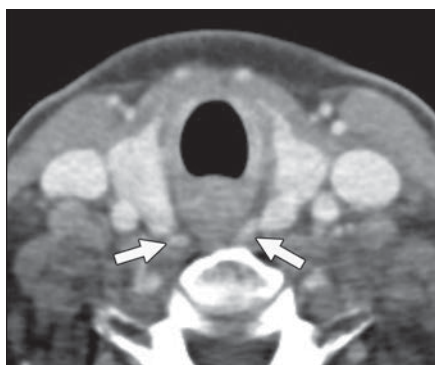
52-year-old woman with history of breast cancer who underwent contrast-enhanced neck CT owing to palpable left supraclavicular abnormality. Axial image shows small bilateral central compartment nodules (arrows) appearing separate from adjacent thyroid gland and exhibiting enhancement different from that of lymph nodes elsewhere in neck. Interpreting neuroradiologist suspected this finding to represent opportunistically identified enlarged bilateral superior parathyroid glands and included in clinical report recommendation for biochemical evaluation for possible primary hyperparathyroidism. Recommended laboratory testing was performed and yielded results consistent with secondary hyperparathyroidism.
